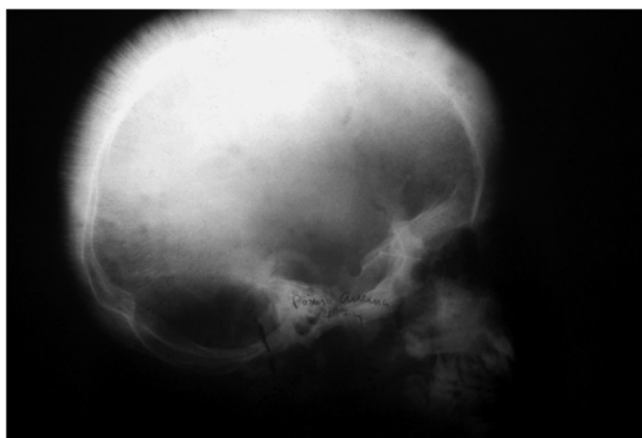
Radiograph of a skull of a thalassaemia major patient showing 'hair-on-end' appearance.
